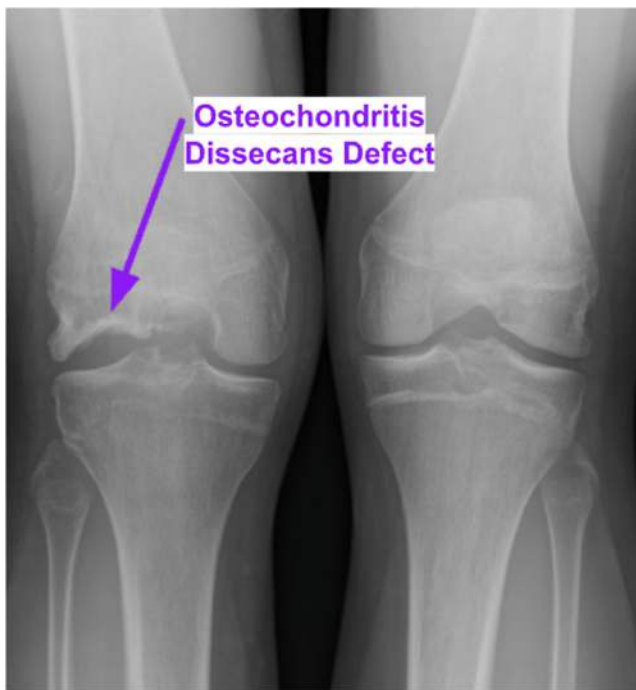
Rosenberg radiograph with bilateral knees bent at 45°. A failed osteochondritis dissecans fixation can lead to loose bodies and eventually osteoarthritis. The degree of osteoarthritis should be evaluated before surgery. Rosenberg radiographs require the knees to be partially flexed, allowing for better visualization of the joint space and assessment of osteoarthritis. In this patient, Rosenberg radiographs show an obvious osteochondral defect of the right lateral femoral condyle.
